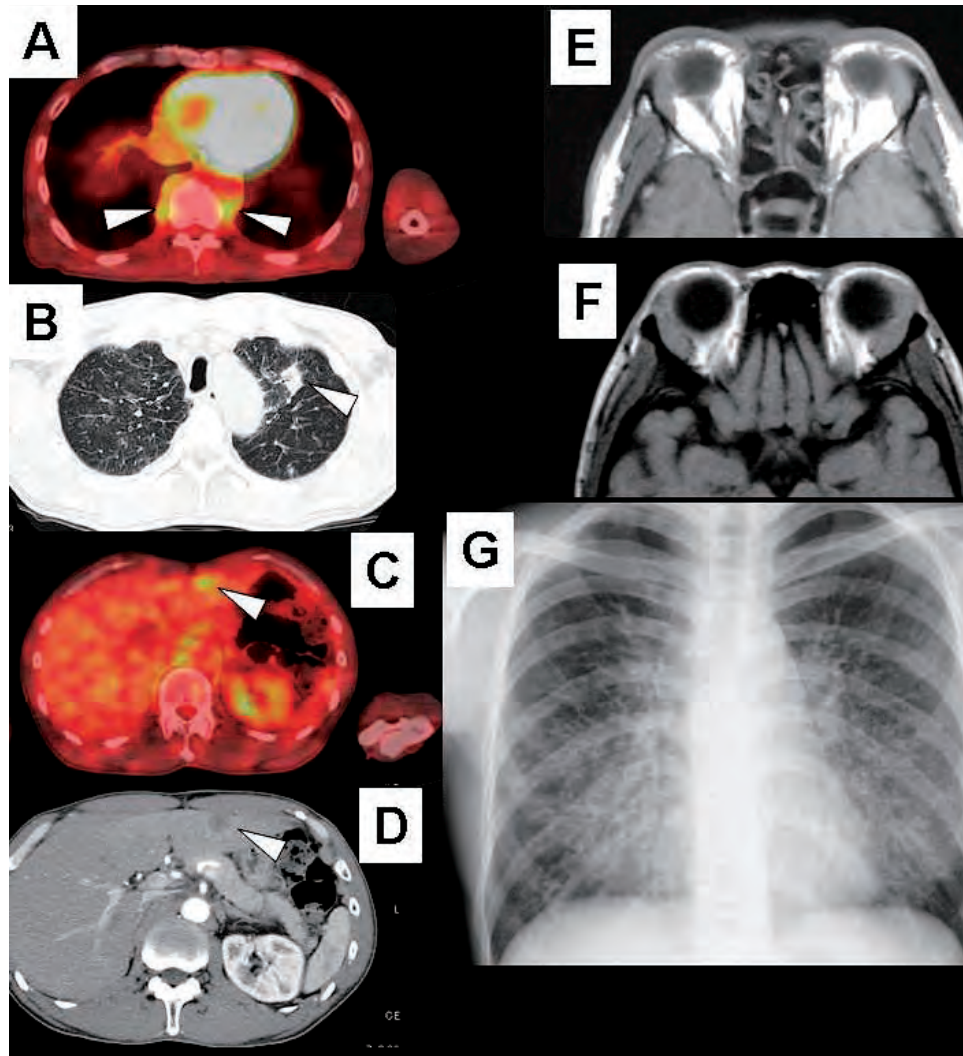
A 48-year-old man (Case 5) presents a left upper pulmonary lobe mass (7B, arrowhead), proven to be adenocarcinoma, together with bilateral interstitial lung disease (7B), and liver lesions (7D, arrowhead) on computed tomographic scans. Fluorodeoxyglucose positron emission tomography fused with computed tomography shows high uptake on bilateral hilar and mediastinal regions (7A, arrowheads, the maximum standardized uptake value : SUVmax = 2.8-3.5) and in the liver (7C, arrowhead, SUVmax = 3.0). He also shows bilateral lacrimal gland masses on T1-weighted magnetic resonance imaging (7E). A 32-year-old woman (Case 7) shows bilateral lacrimal gland masses on T1-weighted magnetic resonance imaging (7F) and bilateral interstitial lung disease on plain chest X-ray film (7G).
